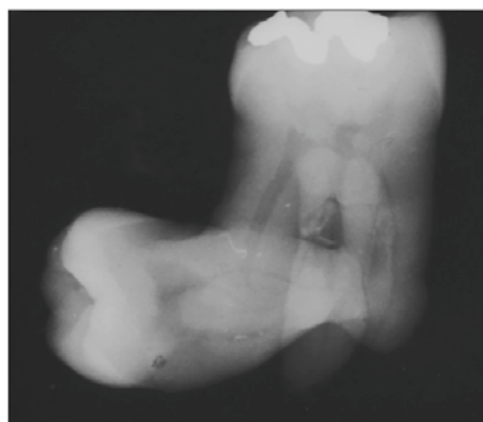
Periapical radiograph depicting molar concrescence.
